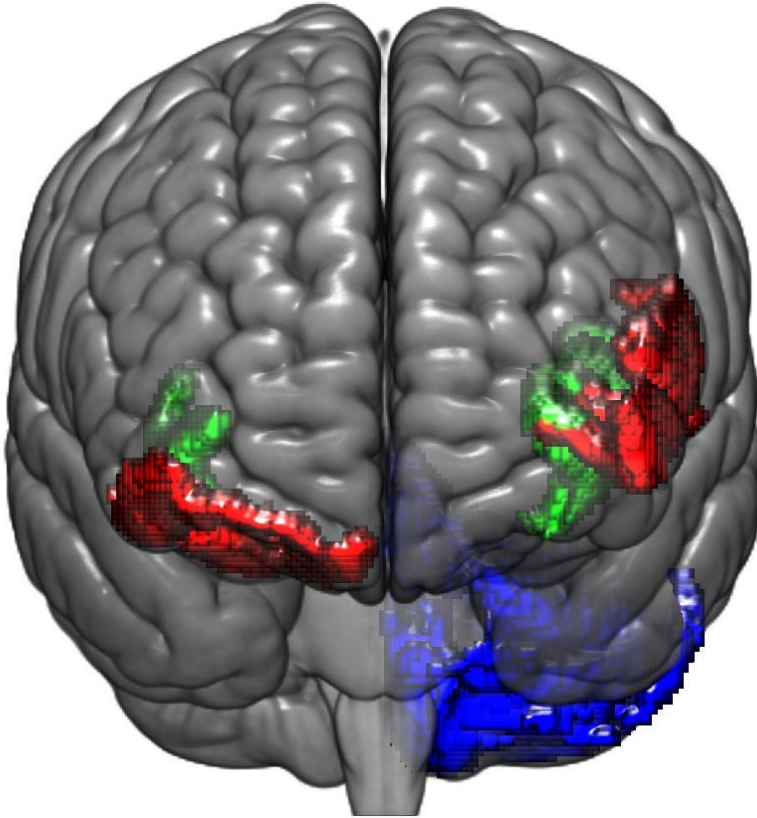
An overview of the study of manuscript III. Structural brain MRI scans of IBS patients (n=67) and healthy controls (n=31) were acquired and parcellated using FreeSurfer. Regions of the sensorimotor network were selected as regions of interest. IBS and healthy controls were compared with and without taking psychological distress and sex into account. In IBS patients only, pain threshold and pain intensity rating during rectal barostat distensions, and abdominal pain and bloating from the GSRs-IBS were correlated with subregions of the sensorimotor network.*
